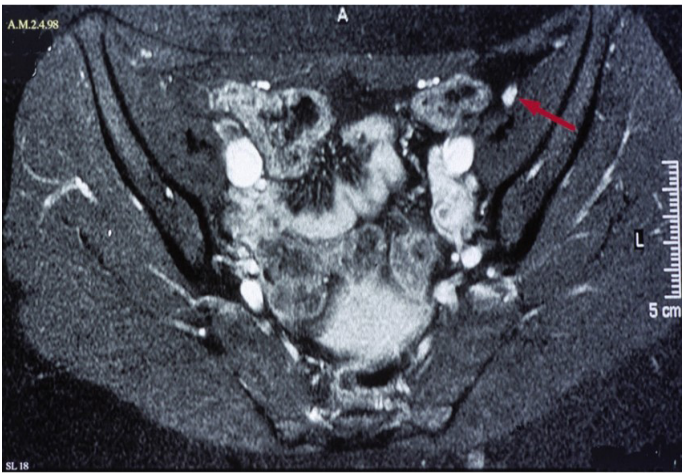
MRI shows the femoral nerve in the T2 weighted sections to be hyperintense for roughly 3 cm above the inguinal ligament and slightly thickened (red arrow).
